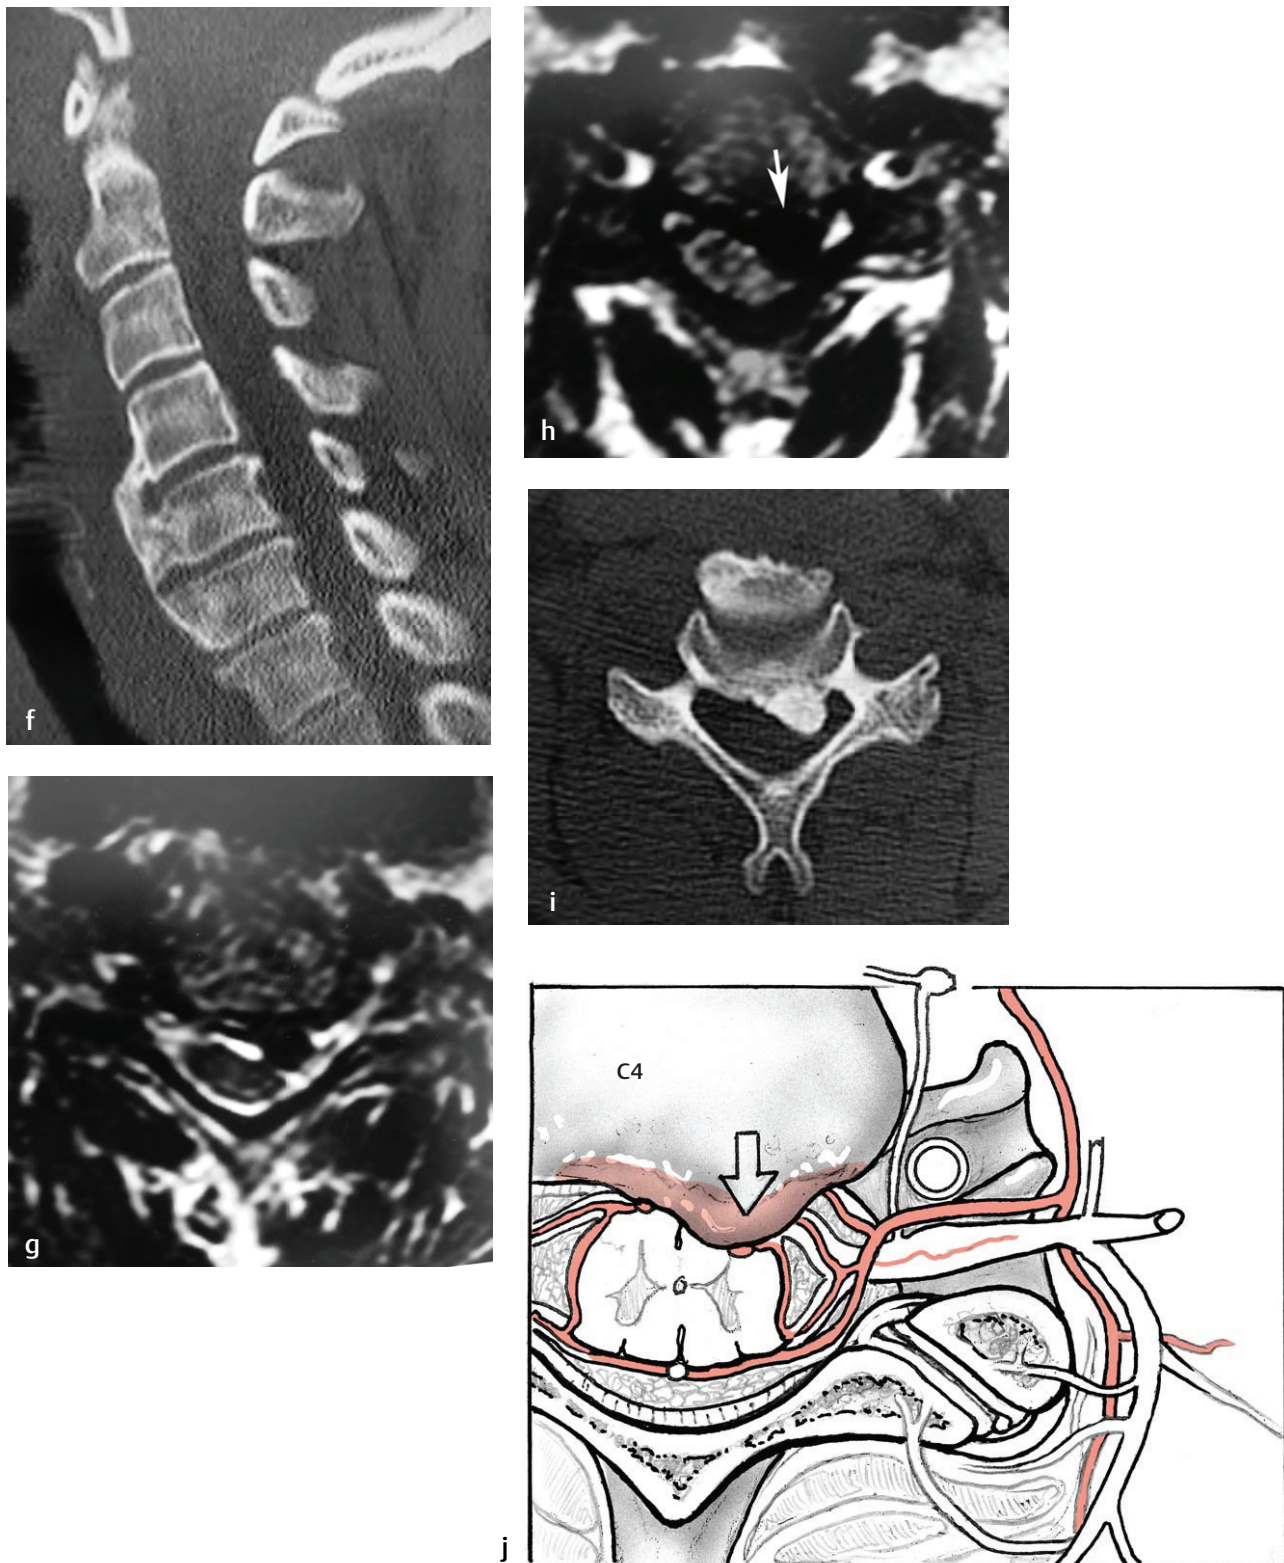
(Continued) (f) A midline sagittal reconstructed CT image shows anterior osteophyte formation but no substantial canal stenosis.[†] (g) An axial T2-weighted image at the level of the C4-C5 disc shows similar findings.[†] (h) An axial T2-weighted image shows severe left paracentral stenosis secondary to what appears to be a disc protrusion (arrow) but is actually a focal region of ossification of the posterior longitudinal ligament at the level of the C4 vertebral body.[†] (i) An axial CT image, obtained at the same level as (h),[†] and (j), corresponding artist's sketch, shows that what appears to be a disc protrusion on MRI is actually a focal region of ossification.
